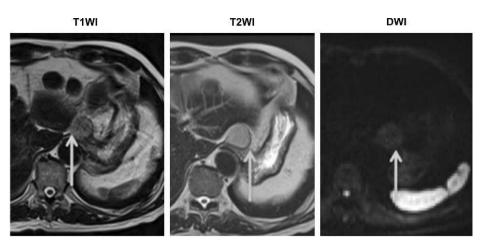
Findings from abdominal MRI with contrast enhancement. The tumor in the gastric cardia shows homogenous high intensity on T2W1 images and isointensity on T1W1 images.
